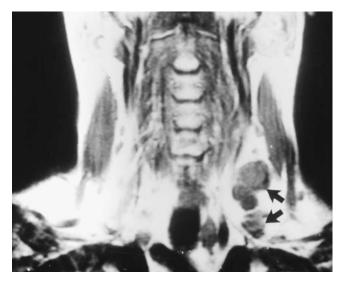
Coronal magnetic resonance image showing leftsided jugular nodal metastases (*arrows*) (levels III and IV) from medullary thyroid carcinoma (MTC) in a patient with multiple endocrine neoplasia type IIA many years after total thyroidectomy for MTC. Calcitonin levels are now elevated. Reproduced with permission from Moley JF, Lairmore TC, Phay JE. Hereditary endocrinopathies. Curr Probl Surg 1999;36:653–764.
